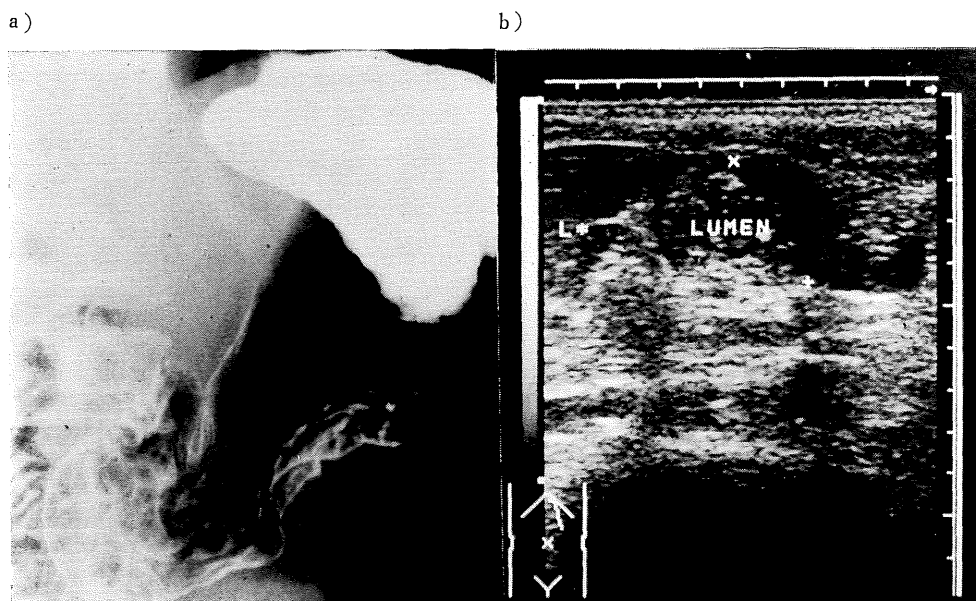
X-ray (a) and ultrasonography (b) of case 3.
